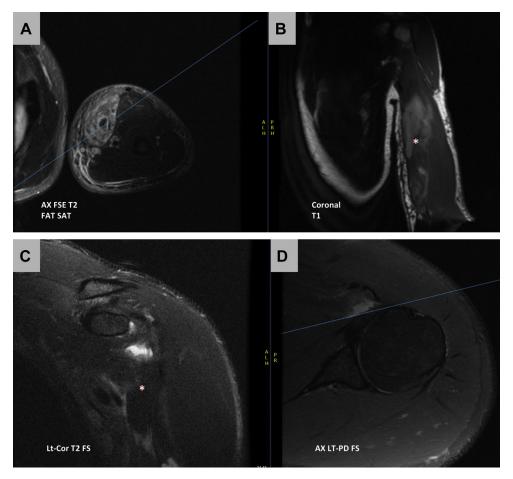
(A-D) Edema and retracted tear of short head of biceps tendon (*) noted on magnetic resonance imaging to anteromedial aspect of arm. One should note the denuded coracoid in C. Ax, Axial; FSE, Fast Spin Echo; FAT SAT, Fat Saturation; FS, Fat Suppression; Lt-Cor, Left- Coronal; LT-PD, Left- Proton Density. The *blue line* in 2A represents the anatomic plane of the corresponding coronal cut in 2B. The *blue line* in 2D represents the anatomic plane of the corresponding coronal cut in 2C.
